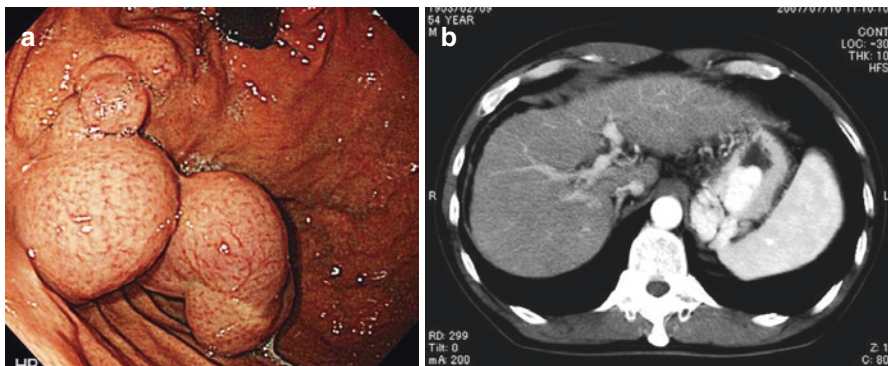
(a) Endoscopic picture before TJO showing large gastric varices. (b) CT before PSE and TJO showing large gastric varices and mild splenomegaly
